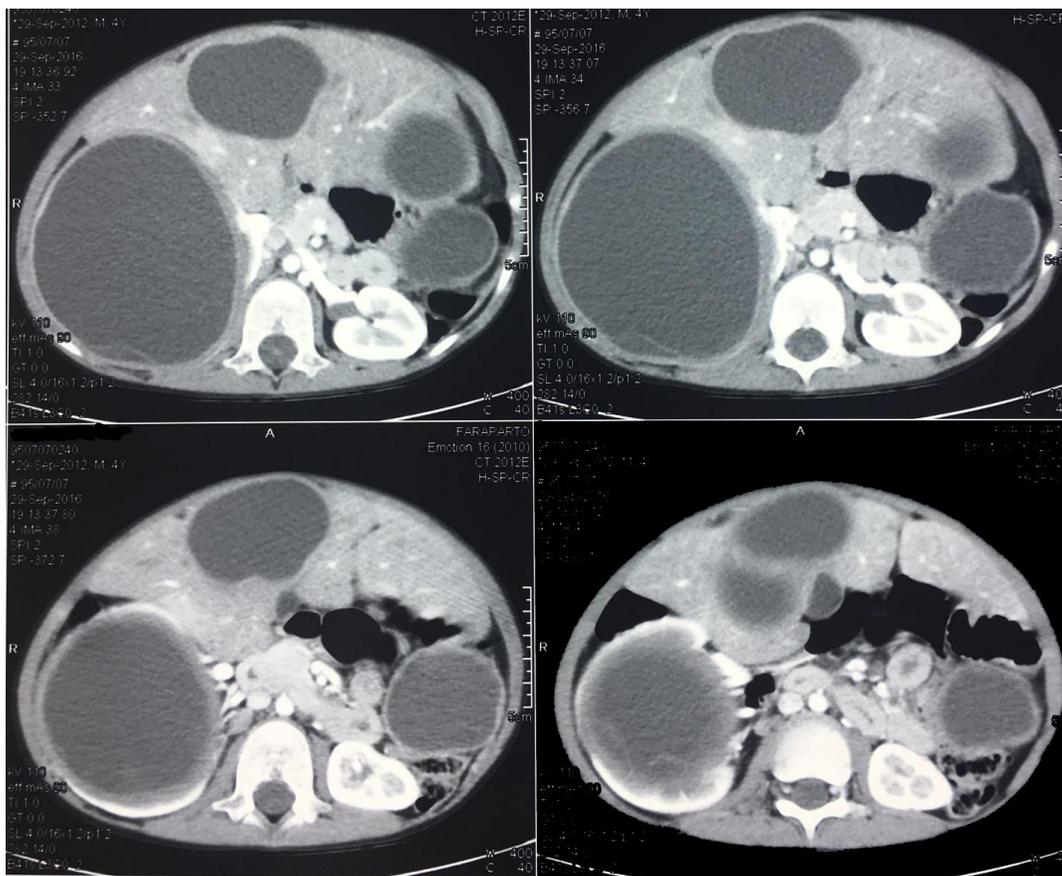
Abdominopelvic CT revealed multiple huge liver and kidney hydatid cyst
